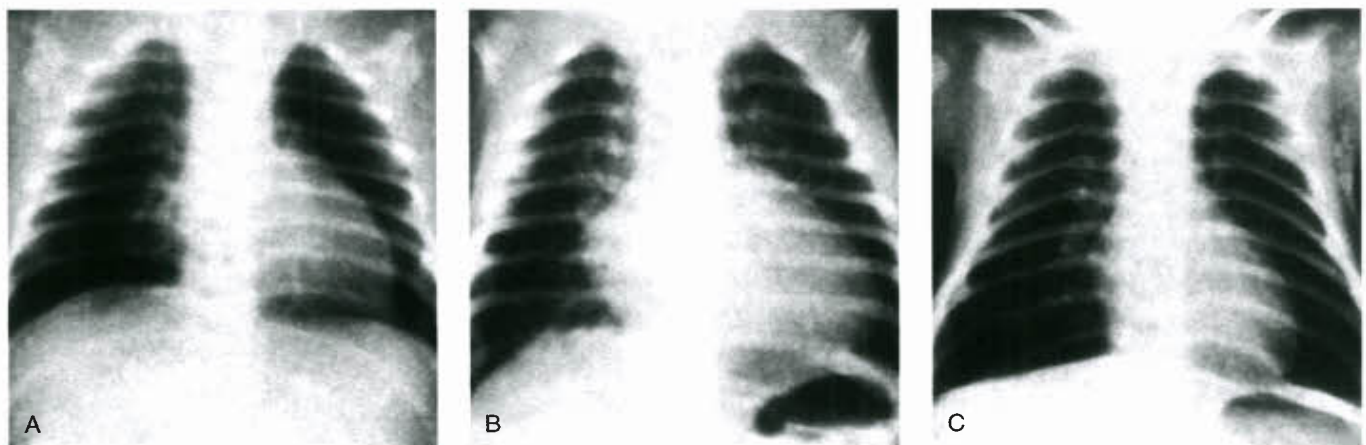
Frontal chest roentgenograms in three neonates with TGA/IVS and no significant PDA at 1 day of age. Note variations in cardiac size, shape, and pulmonary vasculature.
